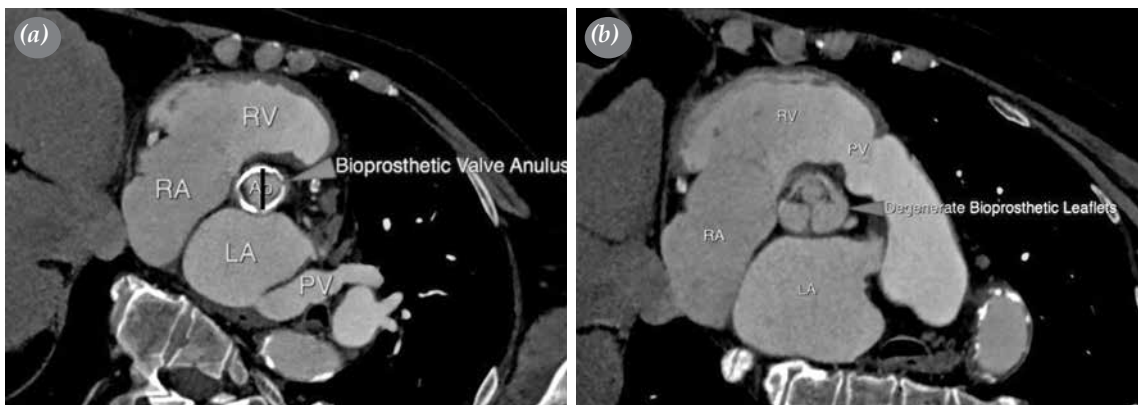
(a, b) Contrast-enhanced computed tomography images showing degenerated bioprosthetic leaflet and annulus.
